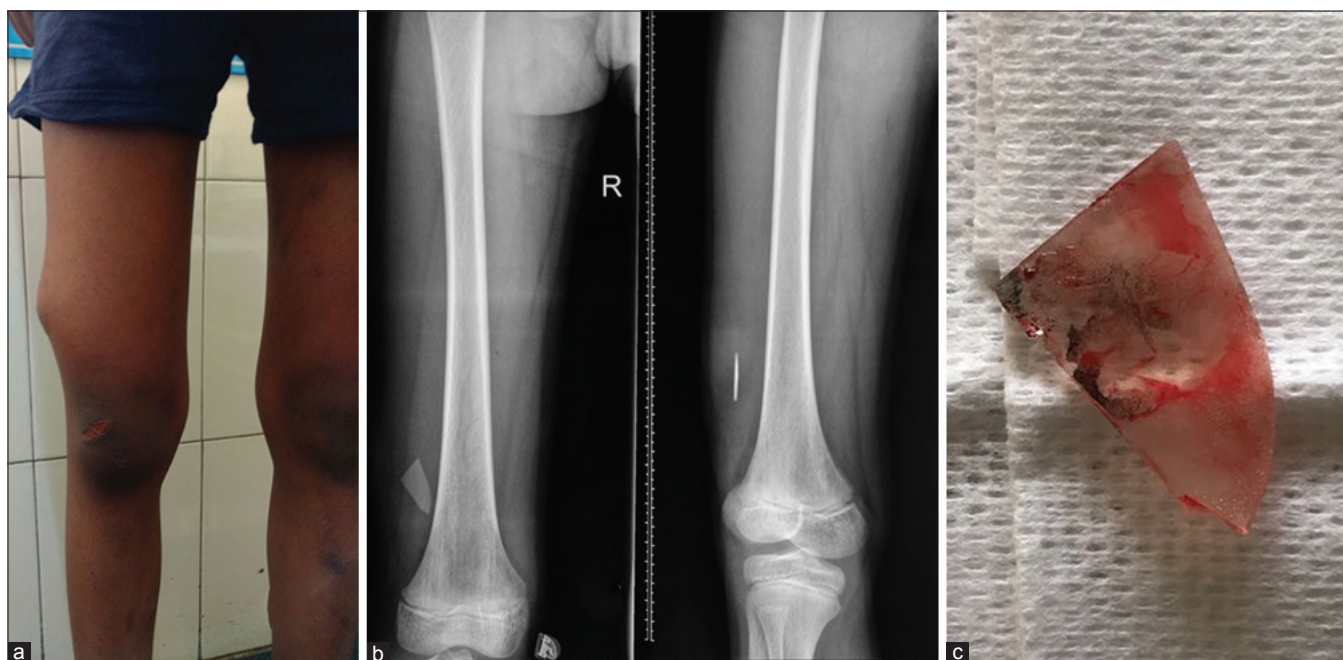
(a) Clinical photograph showing the extremity trauma due to an uncommon foreign body – fire cracker plastic projector. (b) Plain radiographs of thigh with knee joint anteroposterior and oblique views were diagnostic of the plastic material which was opaque. (c) Extracted foreign body
